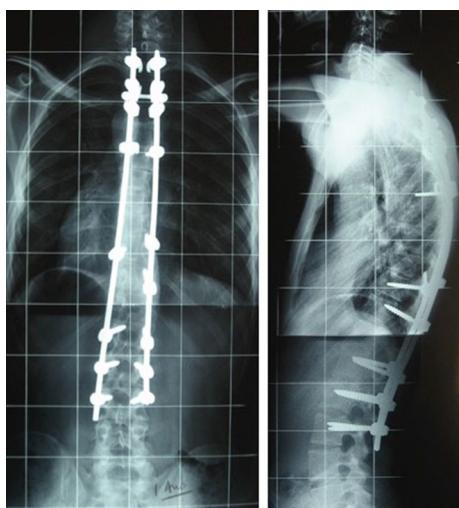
AP and lateral post-operative X-rays showing a T2–L3 posterior spine fusion using a hybrid construction
